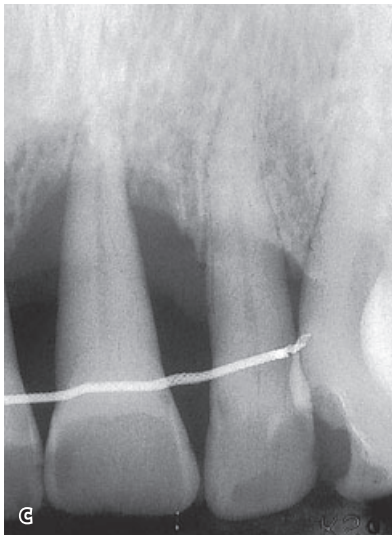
Adult male periodontitis patient after periodontal and orthodontic therapy (a–d). The patient was treated with generalized gingivectomies according to concepts aiming at pocket elimination. The orthodontic result is maintained with a six-unit lingually bonded retainer (d). The bonded wire will act both as an orthodontic retainer and as a periodontal splint, which would appear advantageous in cases where the tissue destruction is as advanced as in this patient. (e) and (f) show the radiographic appearances 7 and 9 years, respectively, after removal of the orthodontic appliances. The left central incisor had so little bone support that if the bonded retainer had not been used, the tooth would probably had been lost over time (see also Fig. 57-8).
